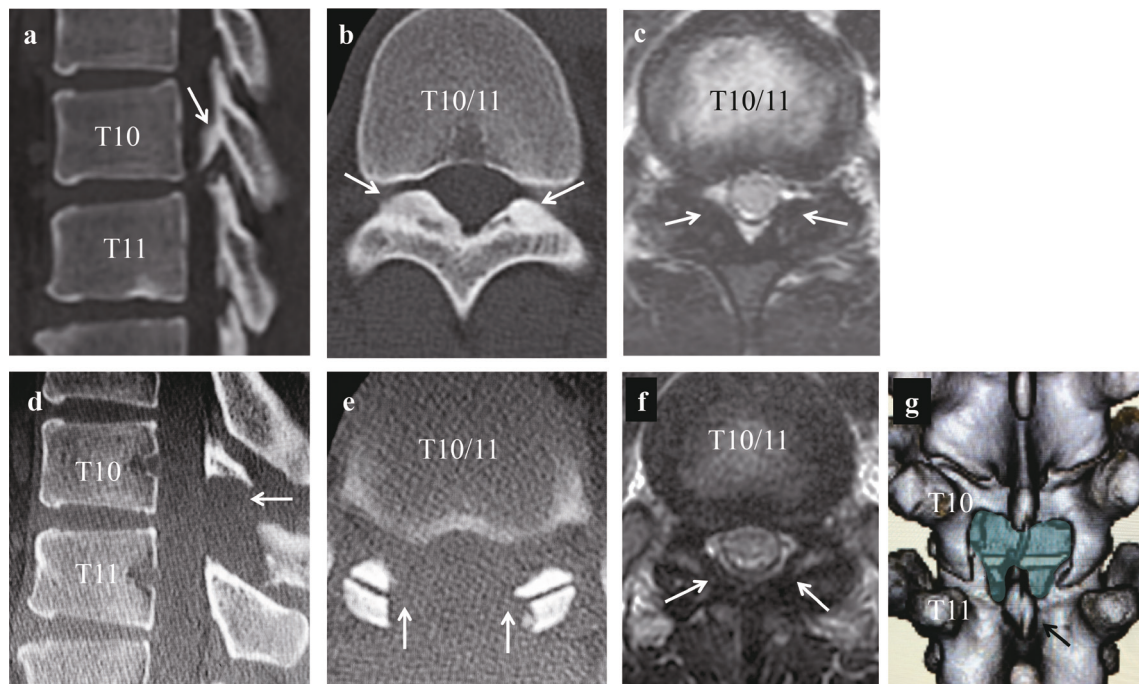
Pre- and postoperative CT and MRI findings of Case 3. Sagittal CT (a), axial CT (b), and MRI (c) show OLF at T10/11 (arrows). Satisfactory decompression is achieved after the spinous process-splitting approach, with no evidence of muscle damage (d, e, f), and 3D-CT of the thoracic spine shows the area of decompression (blue colored) and the re-attached spinous processes of T10 (arrow) (g).
